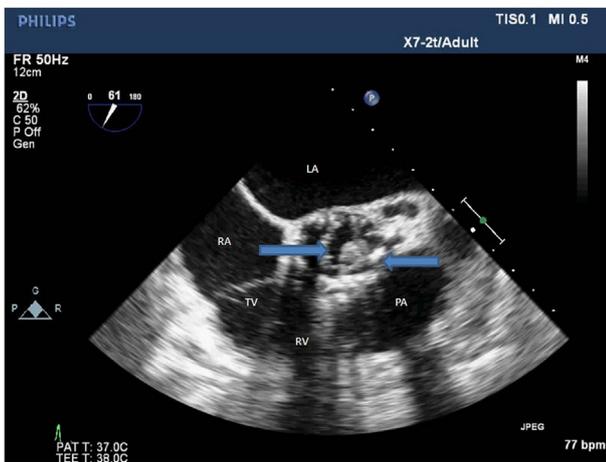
2D transoesophageal echocardiogram from the mid-oesophageal AV short axis view. Arrow pointing right: aortic valve (AV), arrow pointing left: vegetation (Veg), TV: tricuspid valve, RV: right ventricle, RA: right atrium, PA: pulmonary artery, LA: left atrium.
